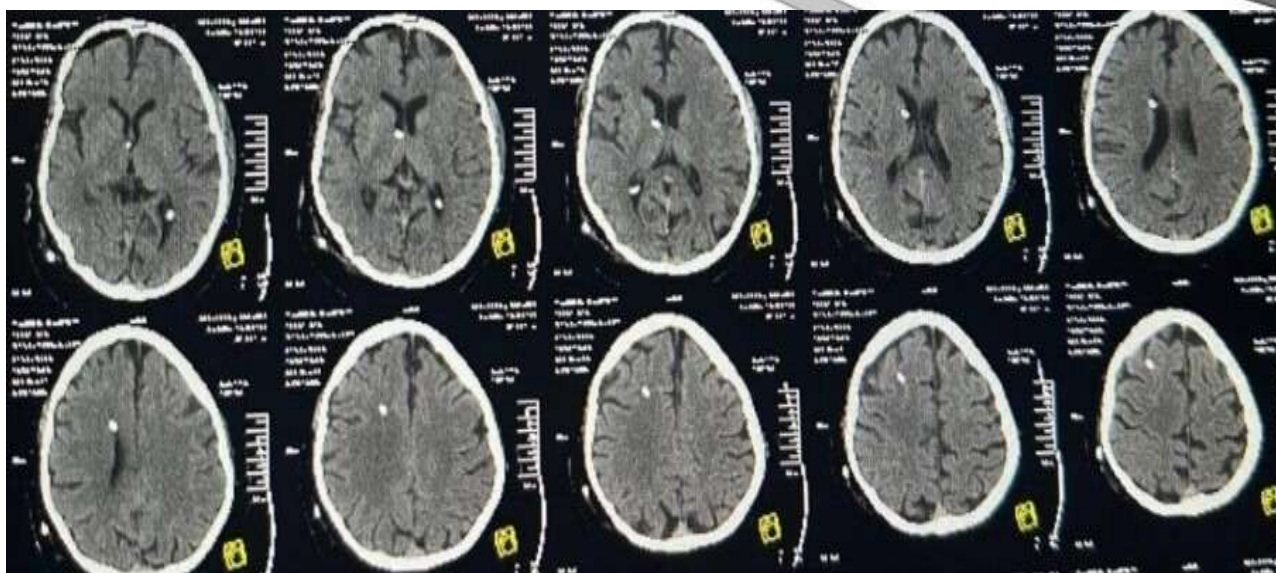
Post-operative CT brain showing intraventricular proximal shunt position (axial)
